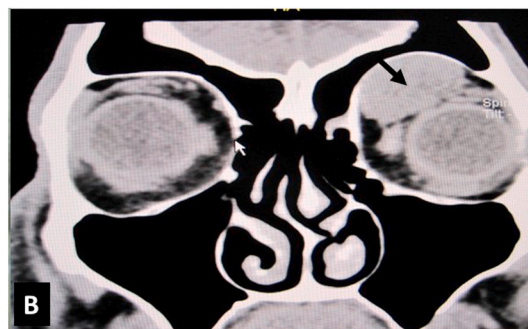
Coronal CT scan with large orbital cystic lesion, marked with black arrow, in the left supero-medial orbit adjacent to the globe with remodeling of the orbital roof.
